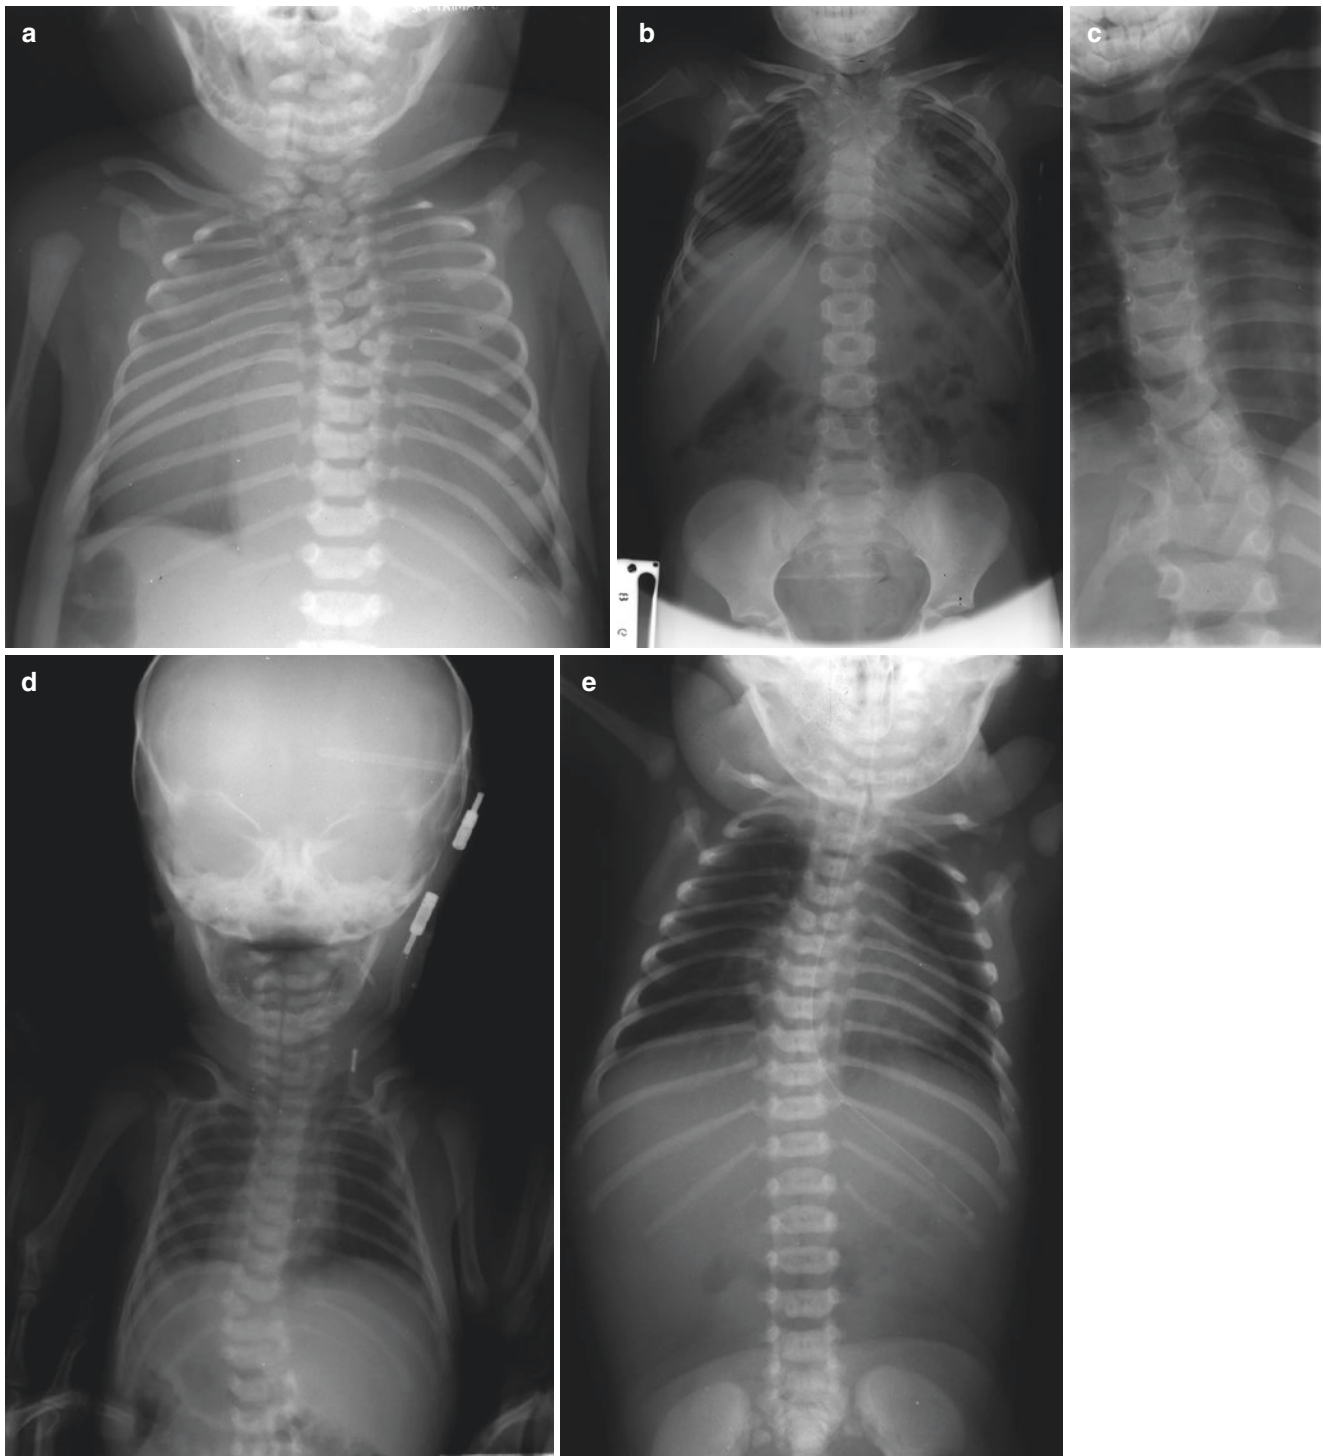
(a) Plain X-ray of the spinal column showing severe disruption of the cervical and the upper thoracic spine with split vertebrae, hemivertebrae, and absence of vertebrae. (b) Severe deformity of the cervical and upper thoracic spine from poor development. (c) Plain
